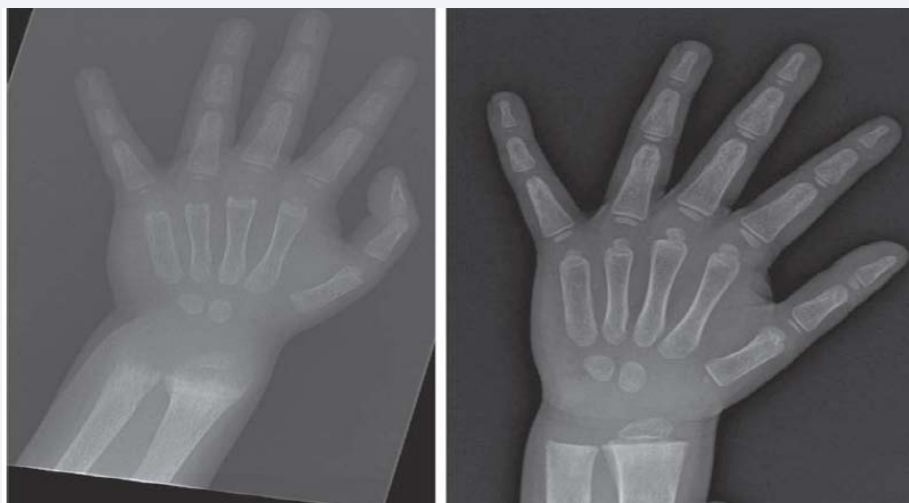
Radiographic manifestations of vitamin D-deficient rickets. Note flaring of the distal metaphyses of the long bones and radiographic response to treatment with vitamin D. Adapted from Sperling M. Pediatric endocrinology.
